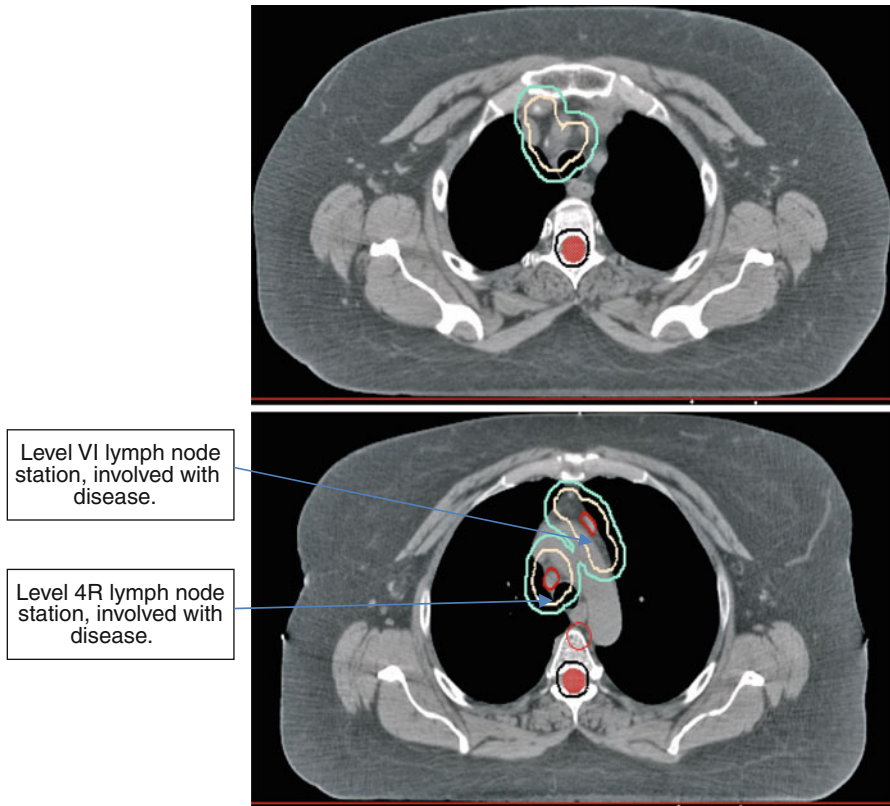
Stage IIIB NSCLC. The patient had a 4-cm right upper lobe tumor with right hilar and subcarinal lymphadenopathy. Lung windows on CT scan are utilized to delineate the primary tumor and hilar region, and abdominal windows can best elucidate the mediastinal nodal stations. *Red GTV, gold CTV, turquoise PTV*
